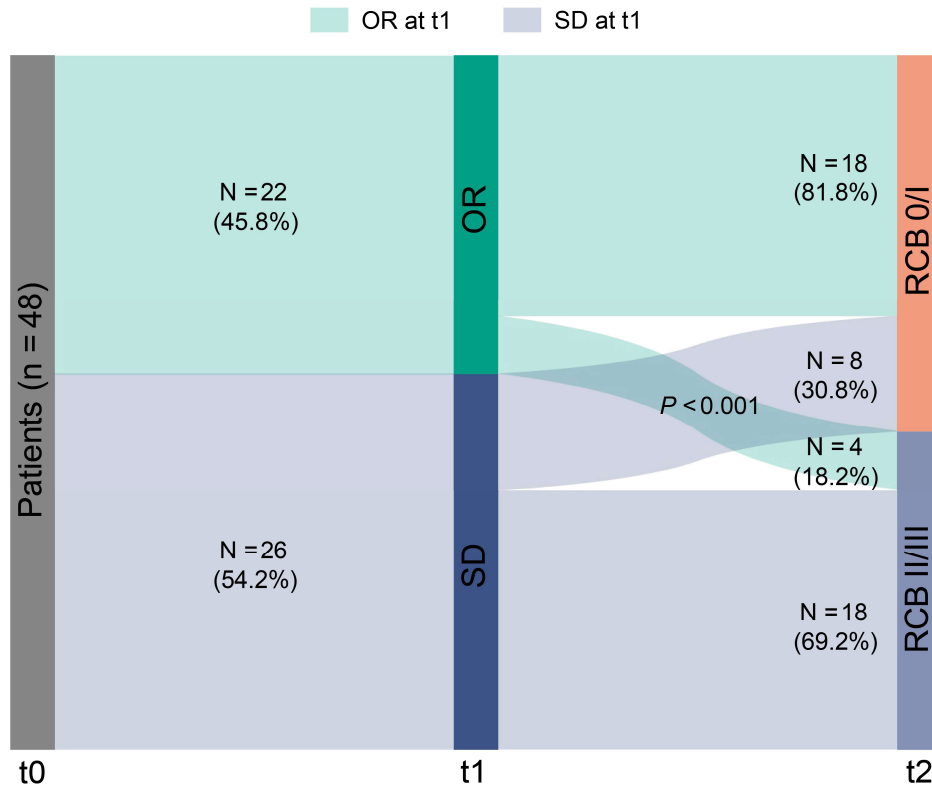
Tumor early response status evaluated by MRI at the end of cycle 2 (t1) versus RCB status at surgery (t2). Related to Table 2.
